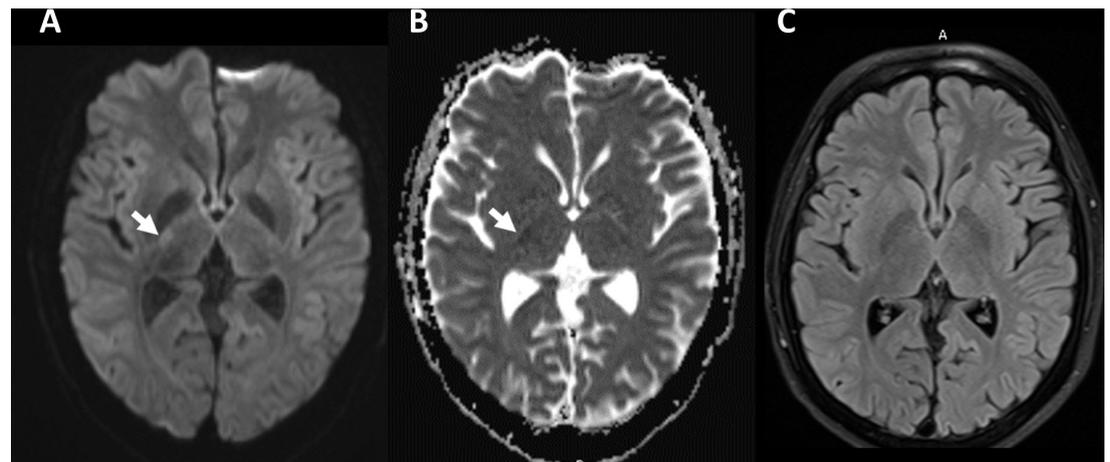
MRI features of atypical methotrexate-induced leukoencephalopathy. MRI demonstrates a small area of restricted diffusion in the posterior limb of the right internal capsule on diffusion-weighted (arrow) (A) and apparent diffusion coefficient sequences (B) without abnormalities on T2-fluid attenuated inversion recovery sequence (C).
